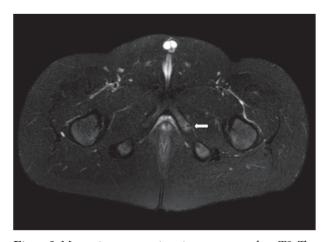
Magnetic resonance imaging transverse plane T2. The lesion is visible as hyperintensity signal (white arrow)
